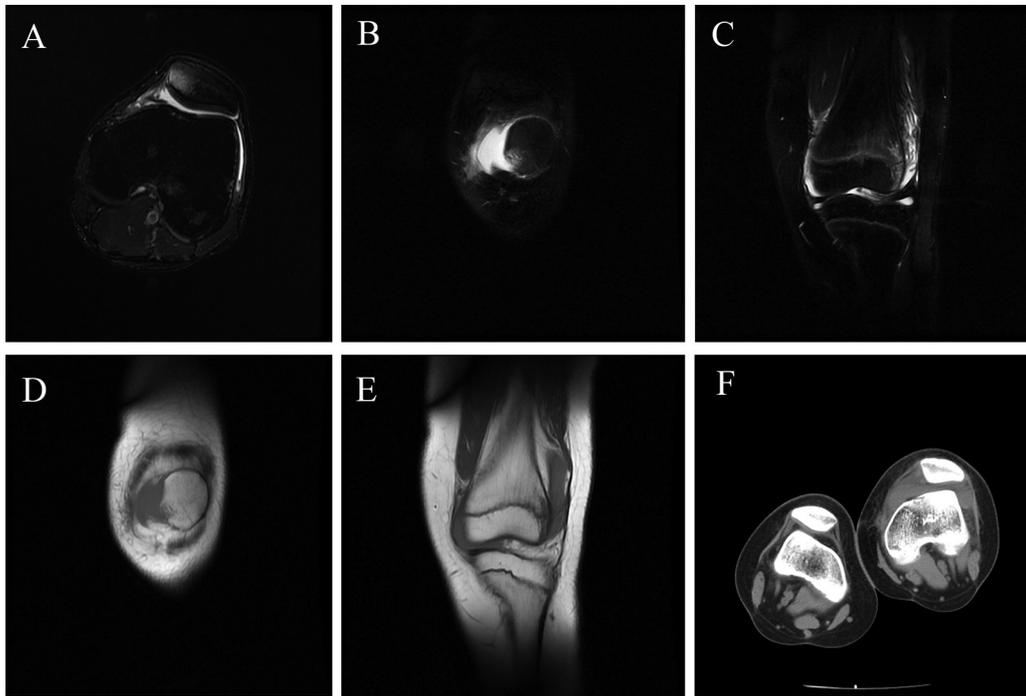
Typical patterns of Type I MPFL injury are shown. (A) Axial T2 MRI indicates bone marrow edema at the medial patellar facet. (B) Coronal T2 MRI indicates bone marrow edema at the medial patellar facet and (C) the anterolateral femoral condyle. (D) Coronal T1 MRI indicates bone marrow edema at the medial patellar facet and the (E) anterolateral femoral condyle. Computed tomography (CT) showed no fracture at the medial patellar facet or the anterolateral femoral condyle.
